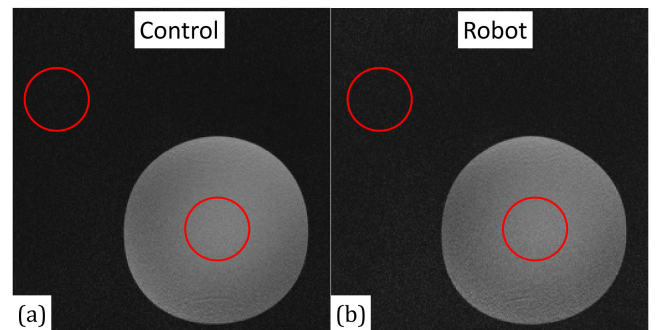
MRI image quality test results. (a) Control and (b) with the robot.
